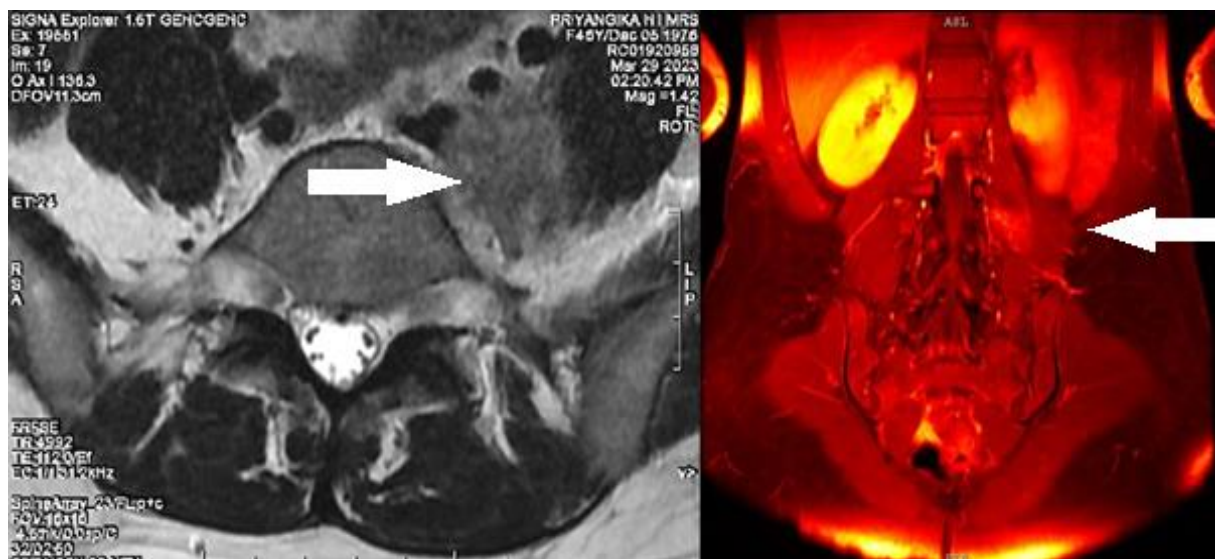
MRI imaging of the patient showing mass formation and muscle infiltration of the left psoas muscle as indicated by the solid arrows.
